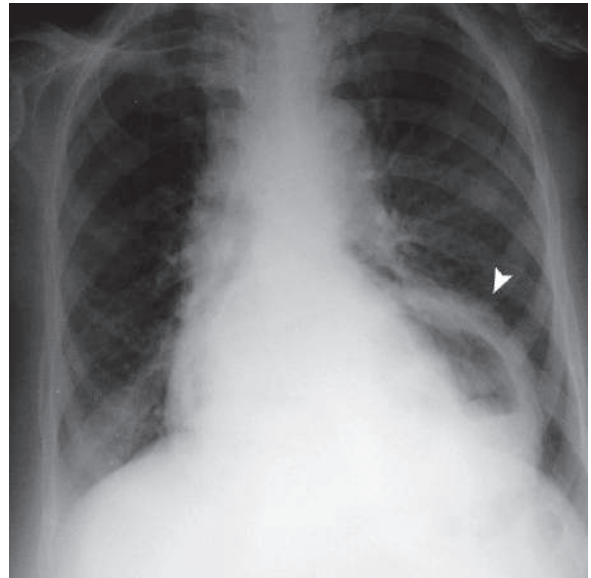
Posteroanterior plain chest radiograph shows herniated stomach into the thorax with the gastric bubble observed in the thorax (arrowhead)
